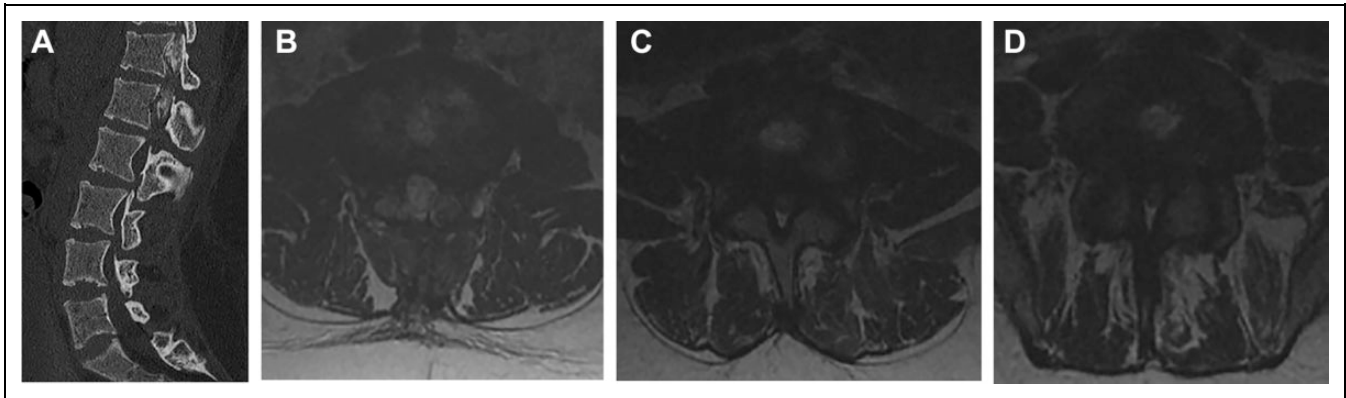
18F with achondroplasia underwent bilateral tibial lengthening procedures with no immediate neurologic changes. However, the patient developed bilateral lower extremity weakness and buttocks numbness 3 days after the lengthening procedures. An urgent CT myelogram was performed, showing partial-complete dye blockage at T12-L2 levels (Figure 2A). The patient underwent an uncomplicated posterior decompression from T10-L3. Neurologically, she continued to improve postoperatively but plateaued with mild weakness in the bilateral lower extremities. An MRI was performed 4 months after the initial procedure showing continued moderate stenosis at L2-3 (Figure 2B) and severe stenosis at L3-4 (Figure 2C) and L4-5 (Figure 2D). The patient underwent revision decompression at L2-3 and decompression of L3-5, complicated by an unreparable dural tear. One year after revision procedure, the patient exhibited improvements in distal right lower extremity strength only.
